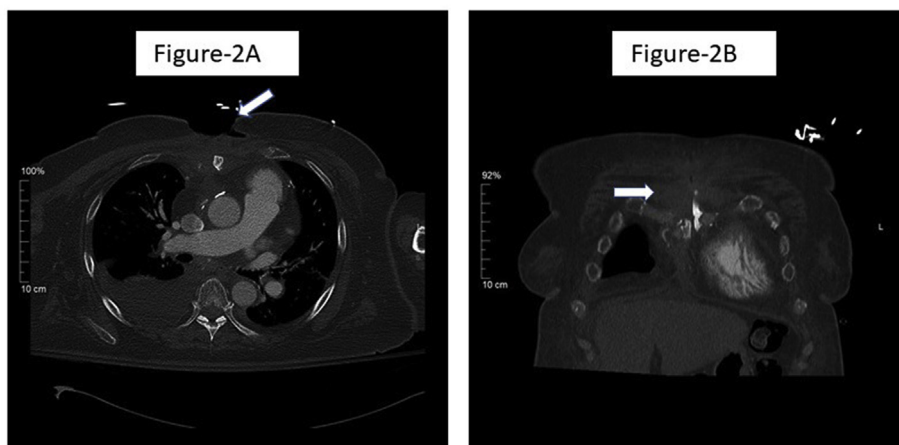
A and B (Day-430), Contrast CT of the chest depicts the post-operative status after sternectomy and worsening of infection and sternal defect.
